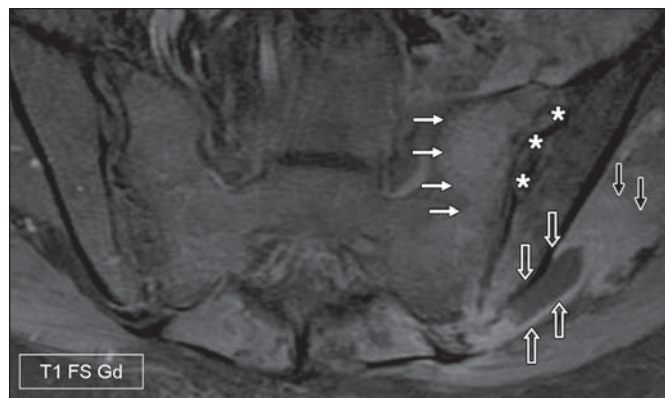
40-year-old woman with infectious sacroiliitis. Axial fat-suppressed gadolinium-enhanced T1-weighted MR image of sacroiliac joints shows bone marrow enhancement of sacrum (white solid arrows), irregularity of articular space of left sacroiliac joint (asterisks), abscess (open arrows), and enhancement of adjacent soft tissue (black solid arrows).
